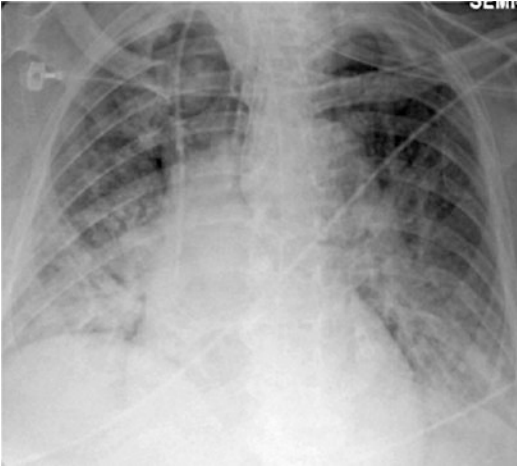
Chest xray on ICU day 5
